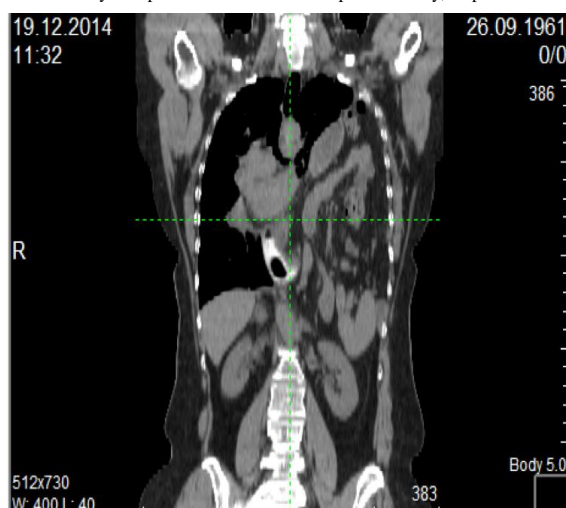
CT scan of the organs of the thoracic and abdominal cavities. The hernial contents in the left pleural cavity are represented by the stomach, the left lobe of the liver, loops of the small and large intestine, spleen, and the tail of the pancreas
